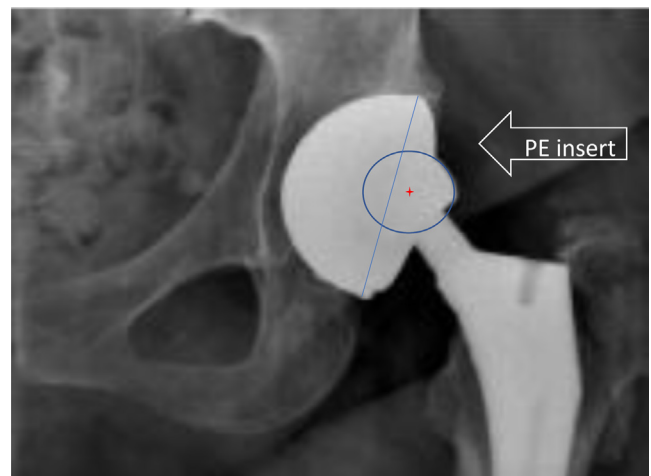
Magnifying postoperative radiograph presented in author's case report figure 2.
